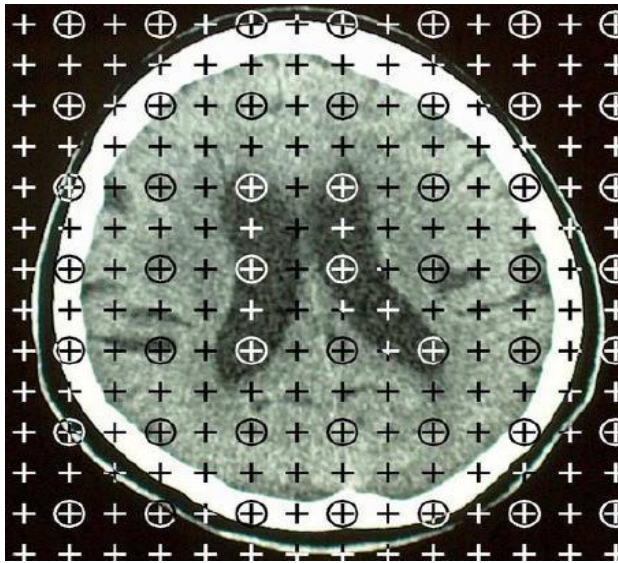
An axial CT scan with a combined point counting grid superimposed on it for the estimation of the VBF.
